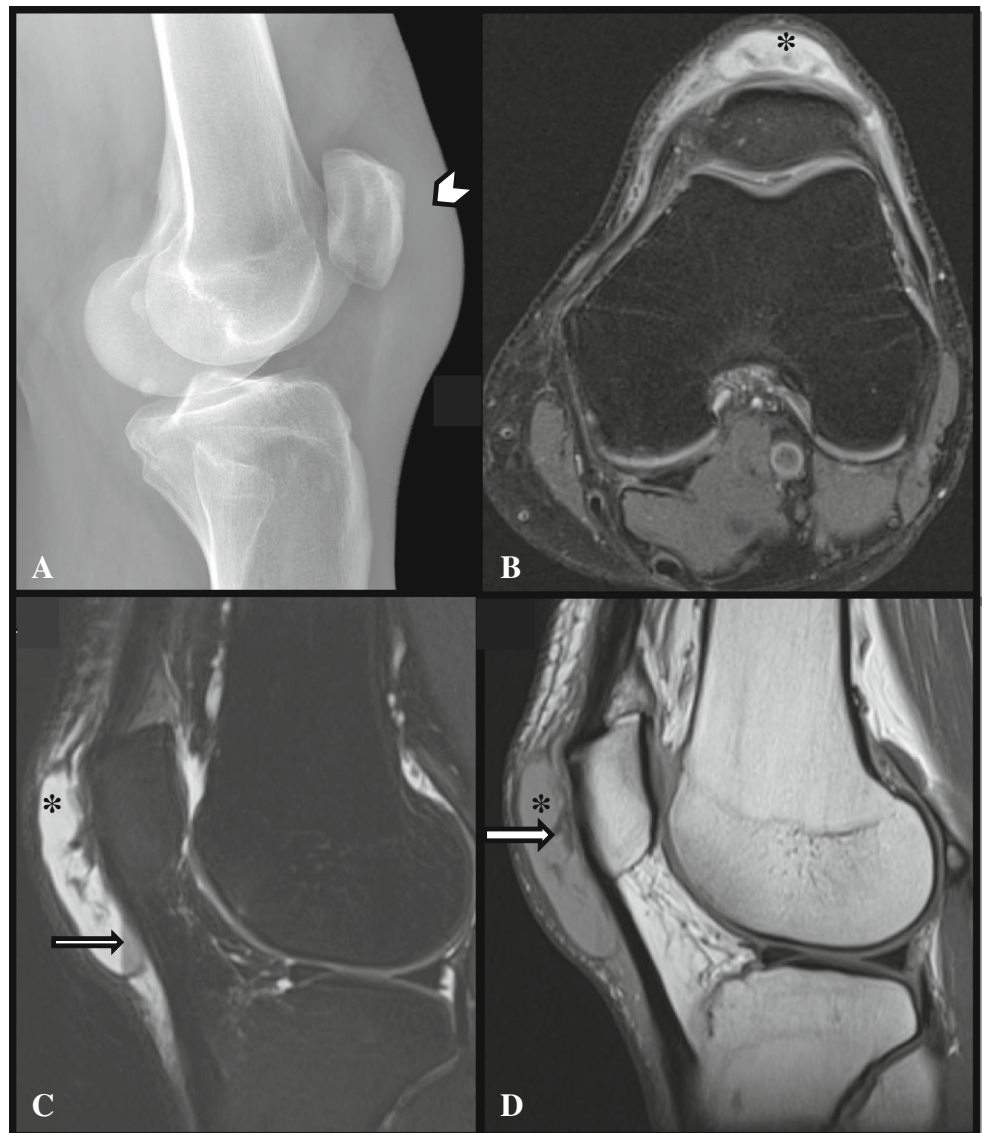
Hemorrhagic prepatellar bursitis (60-year-old patient with anterior knee pain and swelling). a Lateral radiograph shows prepatellar soft tissue thickening (*arrowhead*). b Axial and c sagittal fat-suppressed T2 and (D) sagittal PD-weighted images demonstrating an oval-shaped fluid signal intensity collection in the prepatellar soft tissue (*asterisk*), containing debris and fluid–fluid level (*arrow*) due to hemorrhage
